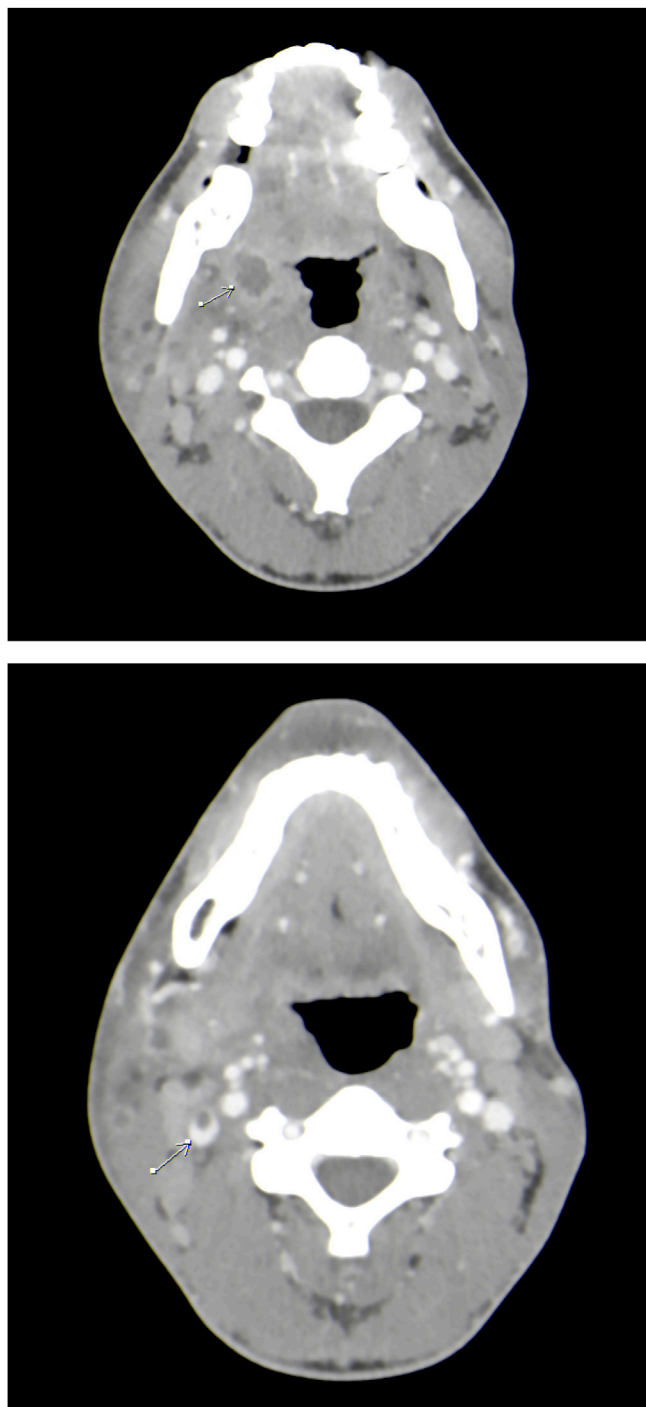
Cervical CT scan showing right tonsillar abscess complicated by thrombosis of the right internal jugular vein.
